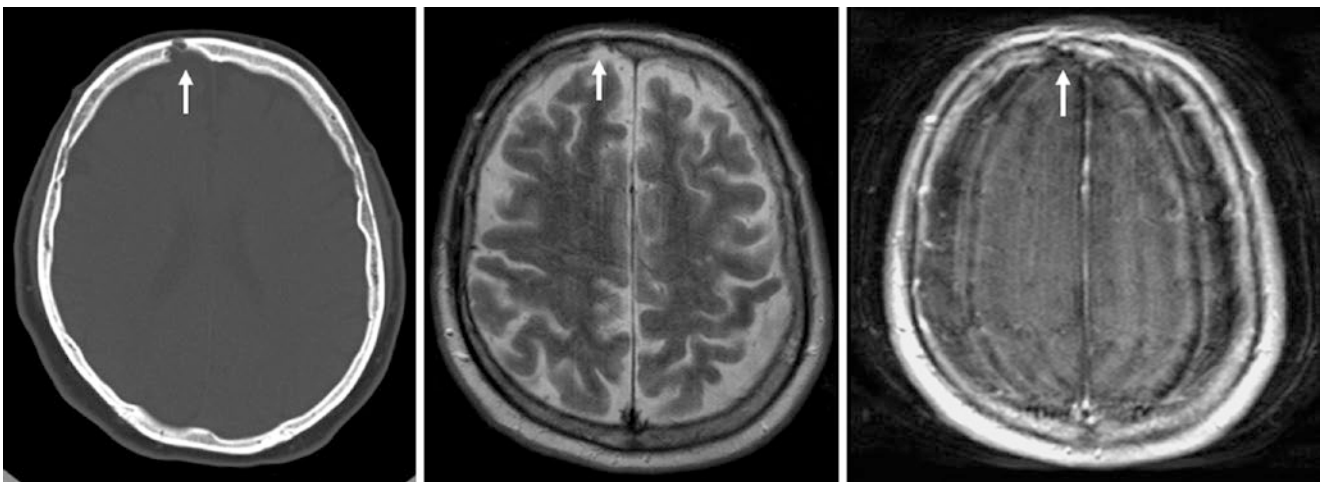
A 61 year old; on an outside NECT (*left*), an arachnoid granulation was initially called a possible metastasis. On MRI, the potential lesion was found to follow the CSF signal on T2WI (*middle*) and FLAIR (*not shown*) and lacked enhancement on T1WI as well (*right*)
